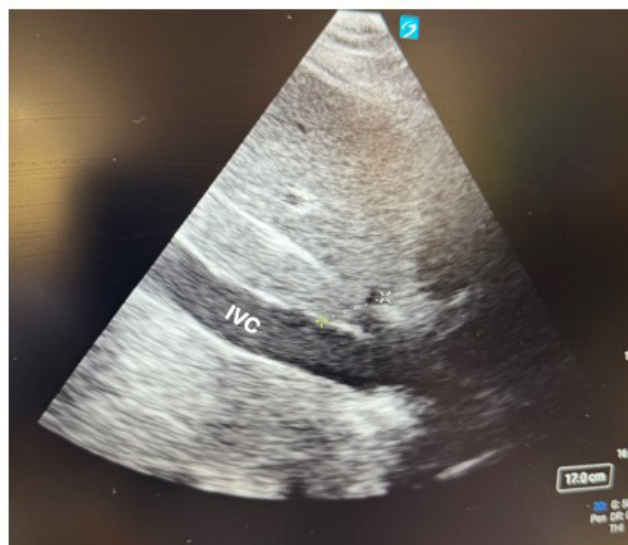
Point-of-care ultrasound can be used to assess volume status by measuring the diameter of the IVC. IVC, inferior vena cava.
